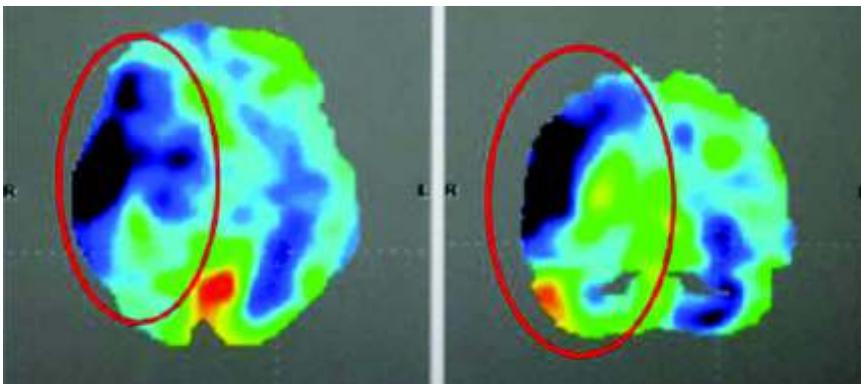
PET-CT scan before Autologous BMMNCs transplantation suggestive of stroke in the region right MCA territory with black areas suggestive of gliosis where as the blue regions suggestive of penumbra
